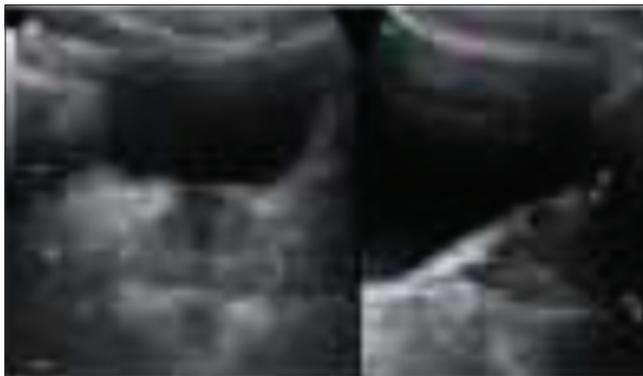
Significant post void volume in transabdominal sonography
